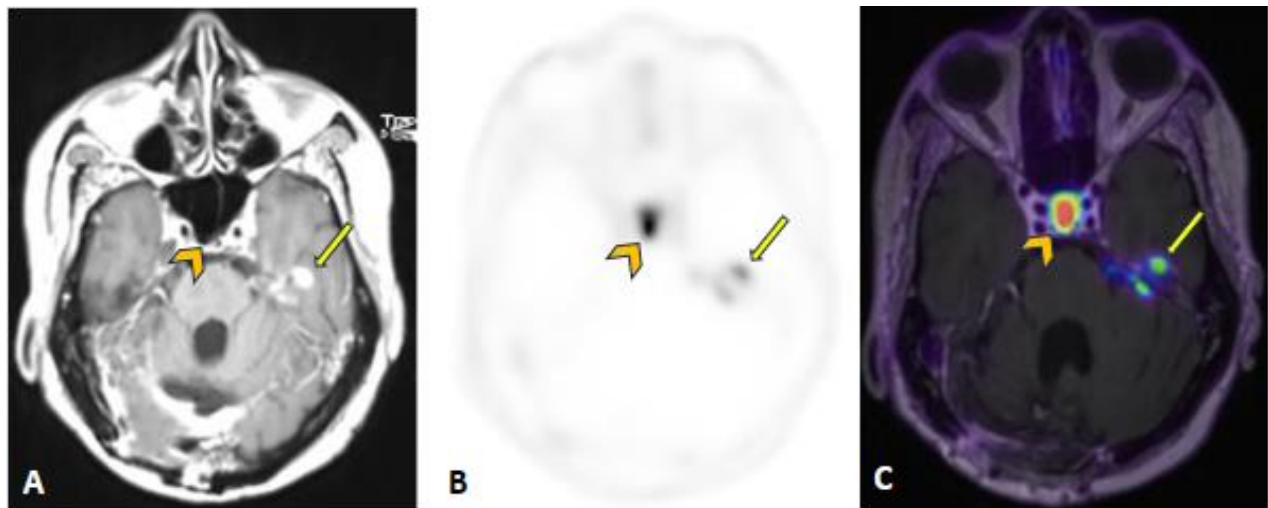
Dural based nodular enhancement along the floor of the left middle cranial fossa, somewhat ill-defined on axial postcontrast T1 (A) demonstrates moderate avidity on PET (B) and fused PET/MRI images (C) represented by arrows. Arrowhead representing physiologic DOTATATE avidity in the pituitary gland.
